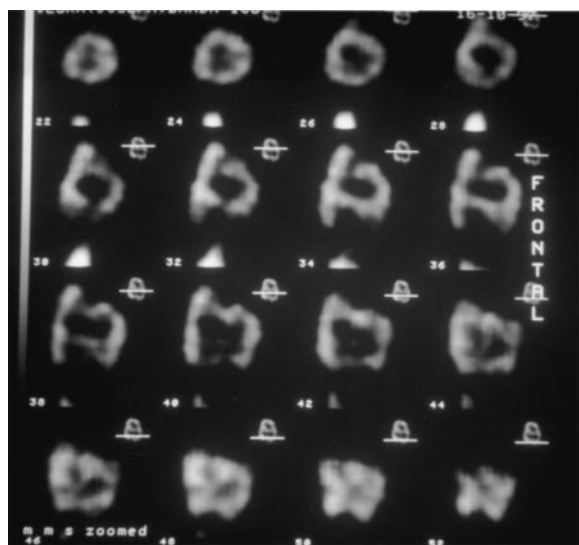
Coronal slices of $^{99}\text{Tc}^{\text{m}}$ HMPAO brain SPECT of twin L.
